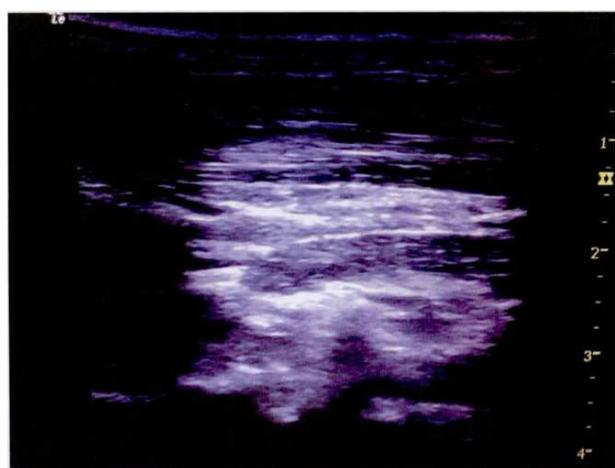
Internal jugular vein retrograde placement ultrasound puncture tube pressure
